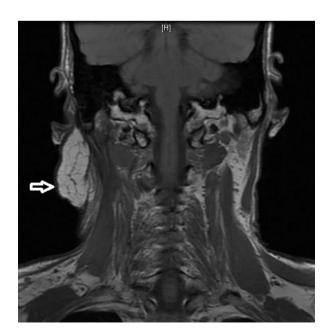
Coronal MRI view after 26 months follow up.
